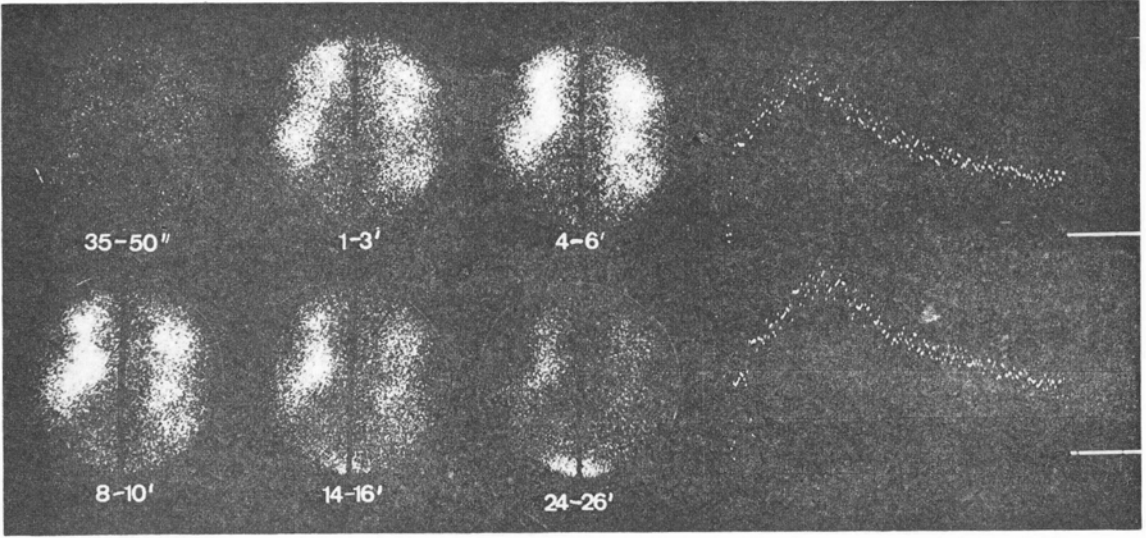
Serial scintigraphy and functional analysis of the right (bottom) and the left (below) kidney in polycystic disease. Note the big defects in the enlarged kidneys, whereas the renal function is only less affected.
